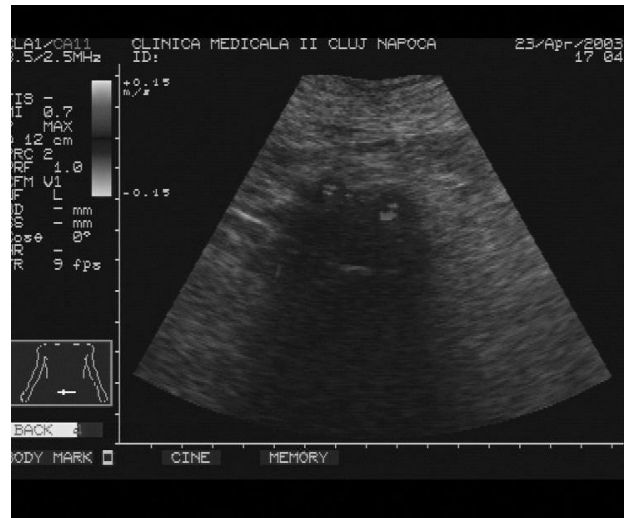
Postoperative echo-Doppler aspect of the permeable forked prosthetic branches.
